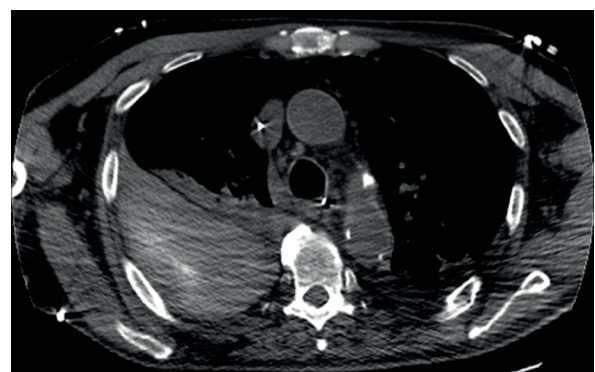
Non enhanced axial CT scan in a polytrauma patient with anemia showing a hematic extra-pleural effusion. Fresh blood is best depicted in unenhanced scans, visible as hyperdense material.
